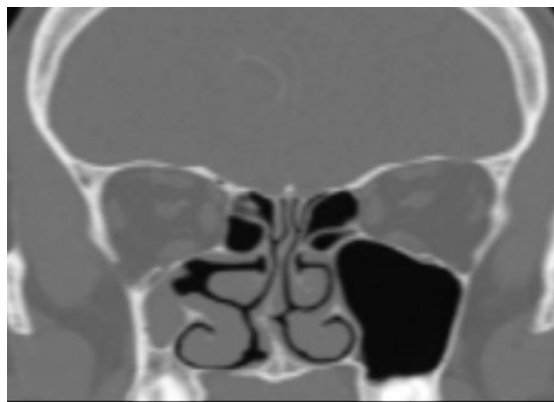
coronal bony CT image with maxillary silent syndrome (<https://radiopaedia.org>)
